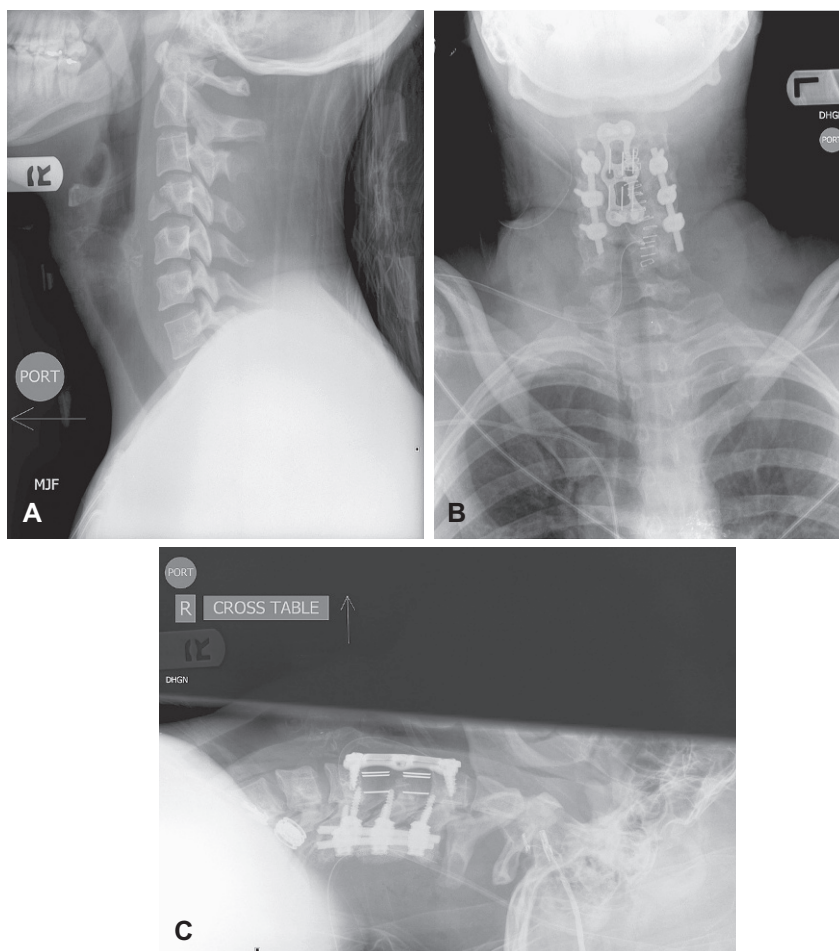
Cervical spine teardrop fracture. A, A preoperative lateral cervical radiograph shows a teardrop fracture of the C4 vertebral body inferiorly. B, An anteroposterior radiograph shows anterior plate and screw fusion from C3 to C5 with prosthetic strut grafts and posterior fusion of the same levels with bilateral pedicle screws and rods. C, On this postoperative lateral radiograph, the anterior plate and screws are clearly visible.
